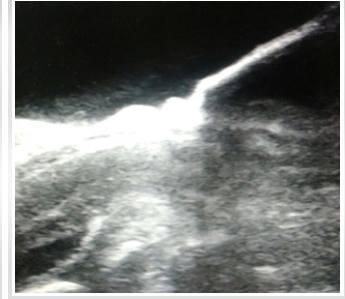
Intra op ultrasound showing significant ventral compression
